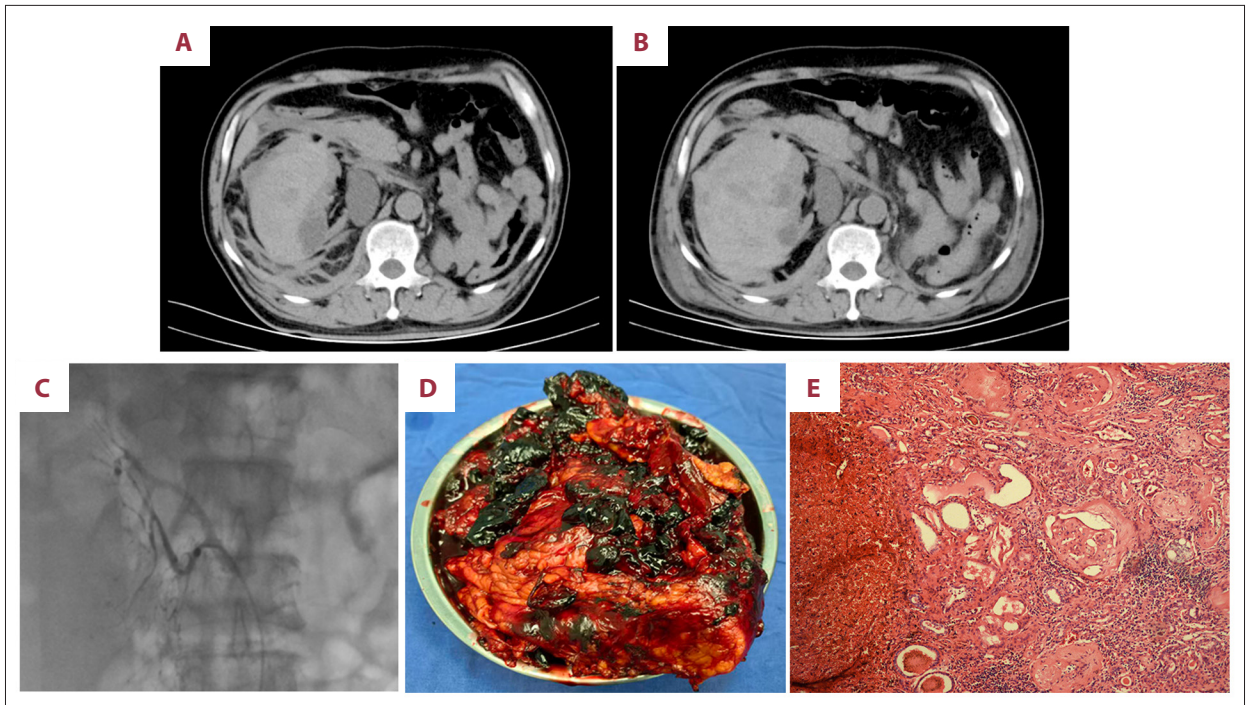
A 68-year-old man with dialysis-associated acquired cystic kidney disease presented with spontaneous intracystic hemorrhage. (A) Computerized tomography (CT) of the abdomen showed a large right perirenal hematoma with a fluid-hematocrit level. (B) CT of the abdomen was re-examined, showing the volume of the subcapsular hematoma on the right side increased. (C) Digital subtraction angiography showed multiple irregular patchy areas of contrast extravasation at the distal end of the right renal artery. (D) Cystic lesions and blood clots were observed at the site of renal rupture. (E) Glomerulosclerosis and tubular dilatation were observed in the renal parenchyma surrounding the ruptured hematoma.
